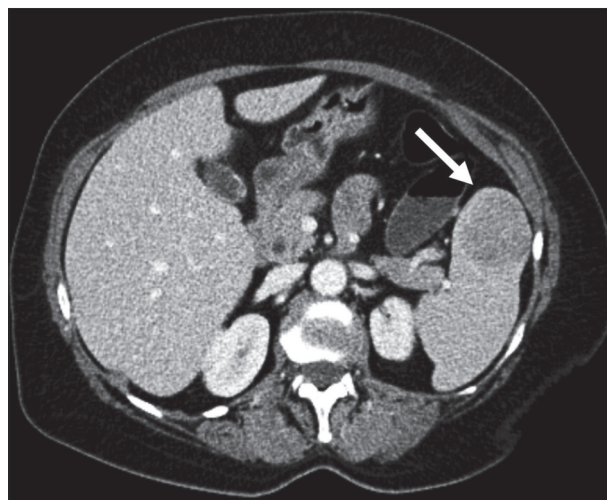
Abdominal computed tomography scan; the arrow points to the change in the upper pole of the spleen
